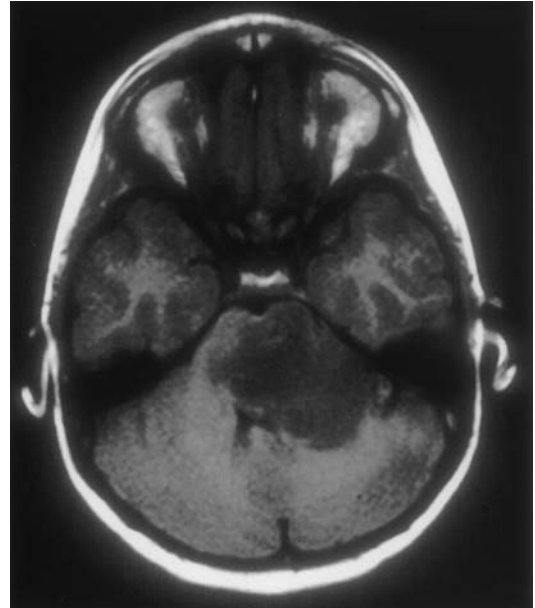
Axial MRI (T1) of an exophytic brainstem glioma. Note the paucity of mass effect, edema and hydrocephalus, typical of these indolent lesions.
